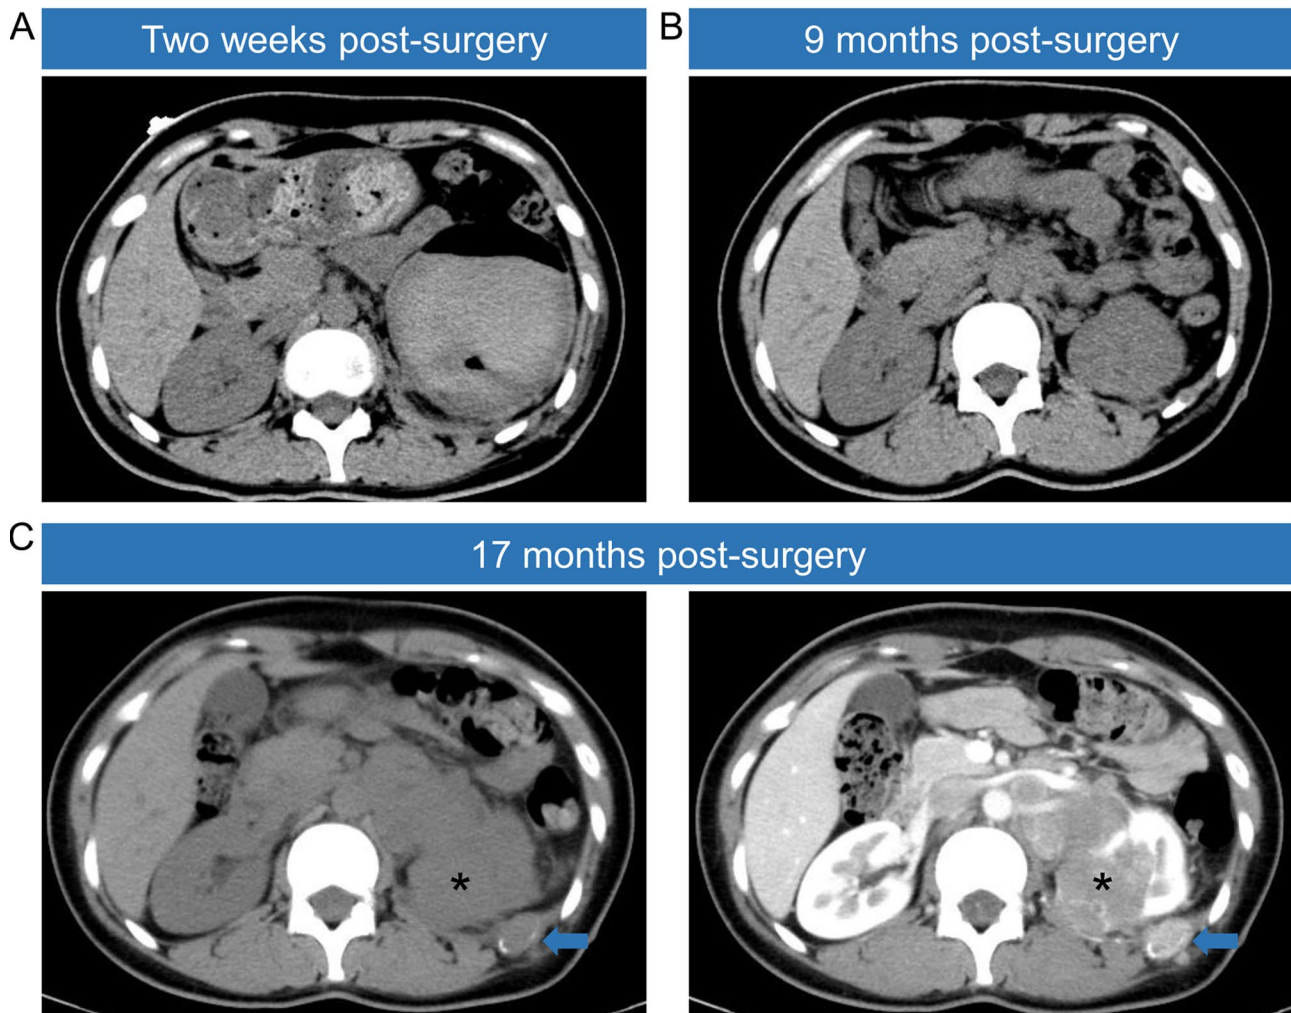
CT images of the patient after surgery. (A) Plain CT image obtained two weeks post-surgery, showing renal subcapsular effusion and pneumatosis, with no signs of tumor recurrence. (B) Plain CT image obtained 9 months post-surgery, showing no signs of tumor recurrence. (C) Plain CT image (left) and contrast-enhanced CT image (right) obtained 17 months post-surgery, exhibiting the recurrent foci in the kidney (asterisk) and the metastatic foci in the left 12th rib (arrow)
